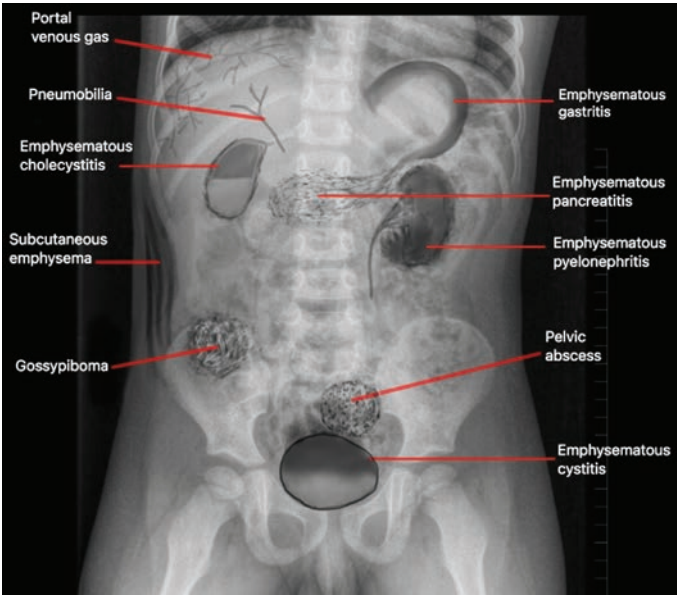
Approach to radiolucency in plain abdomen radiograph
